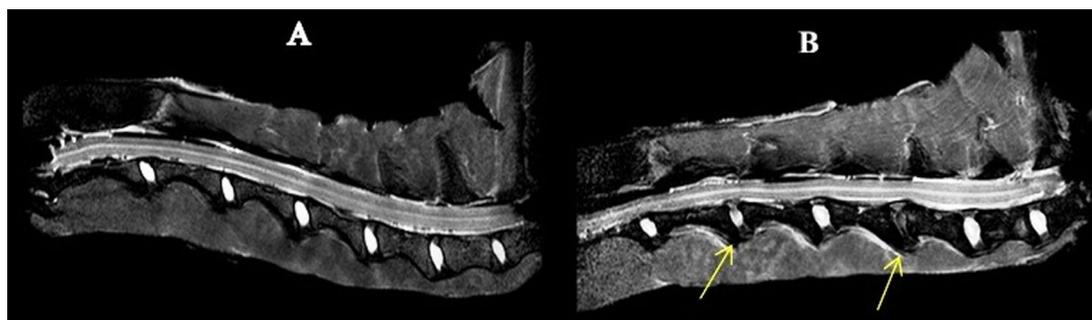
Sagittal T2 weighted MRI image of an *ex vivo* cervical vertebral column demonstrating (A) normal anatomic features and (B) intervertebral disc degeneration at C3–4 and disc degeneration with protrusion at C5–6 (arrows).
